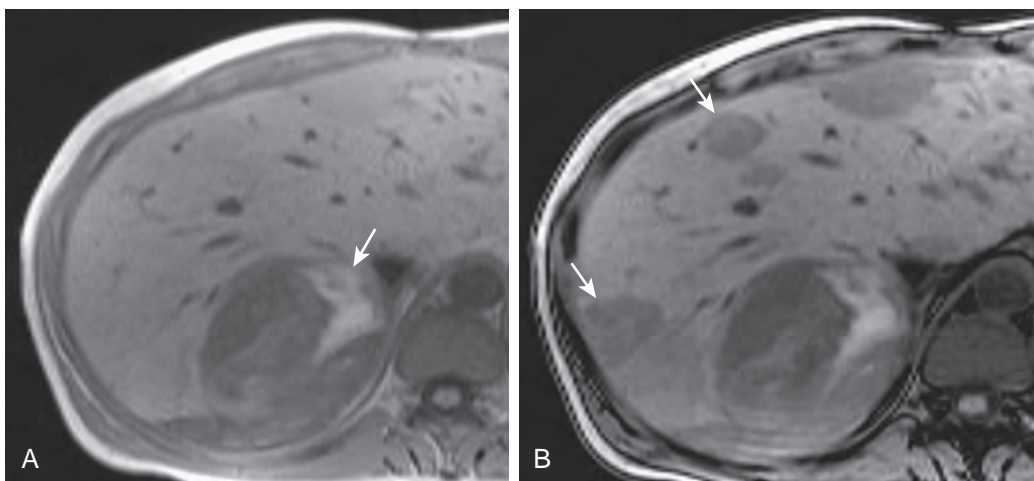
Adenoma: MRI features. A. In-phase image shows high signal intensity hemorrhage (arrow) within this mass. B. Opposed-phase image shows loss of signal intensity of the mass indicating fat. There are multiple areas of focal fatty infiltration (arrows).
